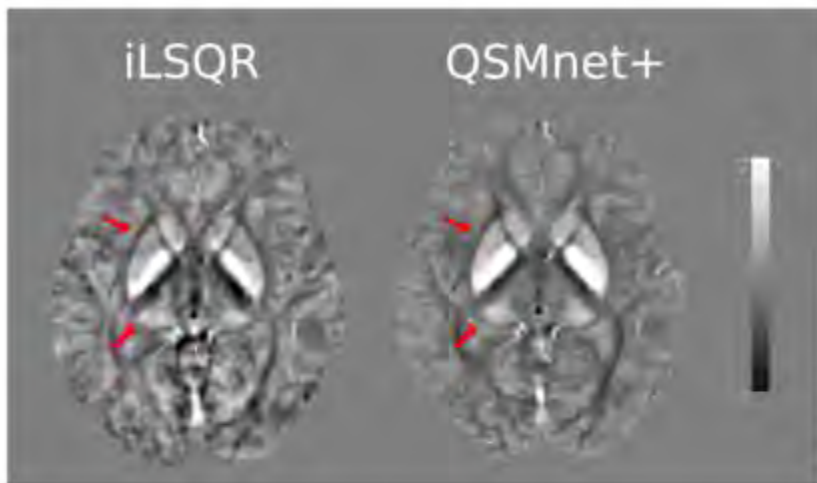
The visualization of the deep gray matter on quantitative susceptibility mapping (QSM) between QSMnet+ and iLSQR algorithms at 7T MRI. QSM acquired by QSMnet+ demonstrated a more accurate and detailed visualization of the deep gray matter and its anatomical border (red arrow).
